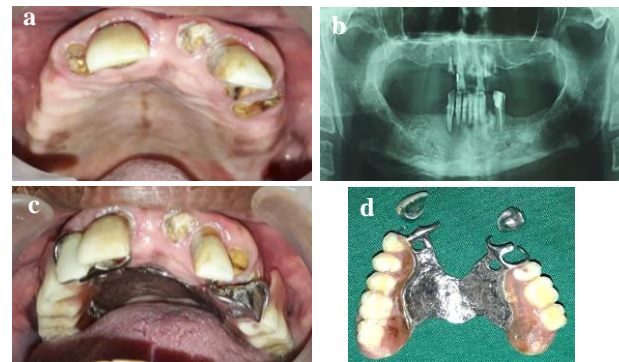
Preoperative situation. a: Remaining maxillary teeth; b: radiographic view; c,d: existing prosthetic restorations
